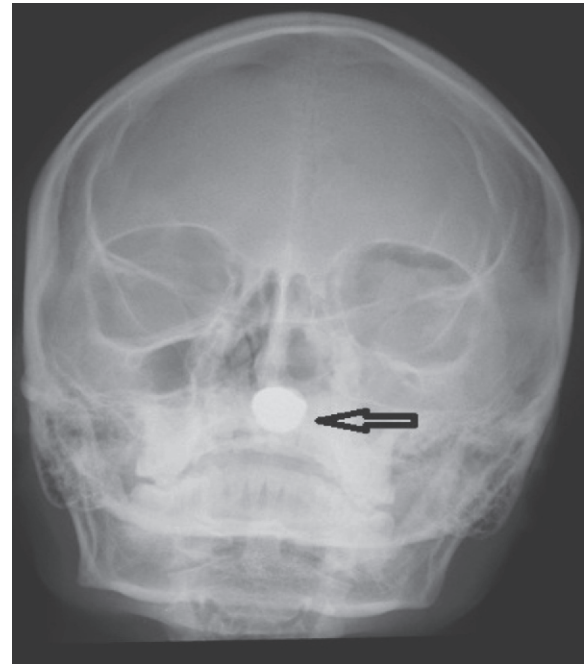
Antero-posterior view of the skull x-ray with the arrow showing the metallic foreign body within the maxillary sinus.
